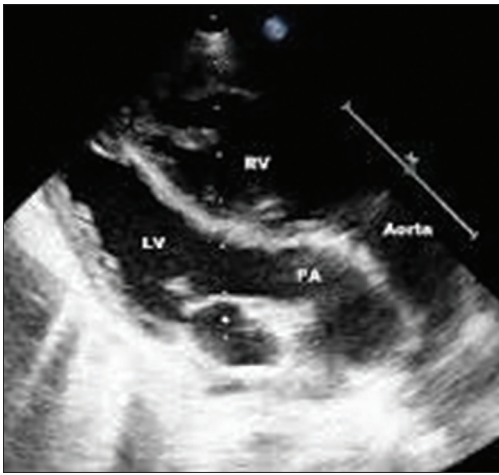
Parasternal long axis view. The left ventricular outflow tract is seen bifurcating into branch pulmonary arteries and has lost its usual tapering
